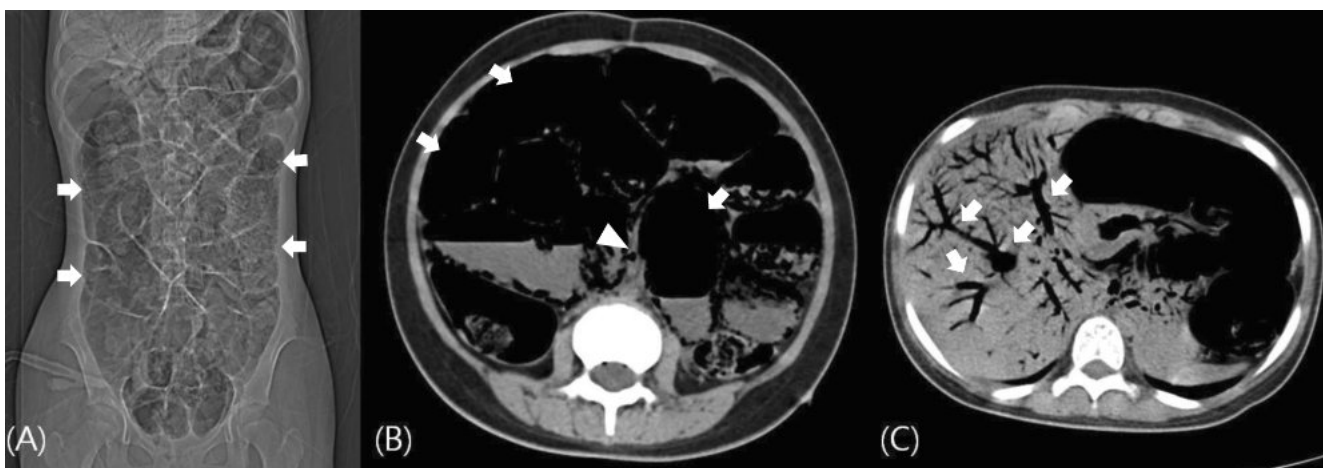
Computed tomography images of the abdomen and pelvis. (A) Aggravated state of gaseous collections in small bowel loops (arrows). (B) Generally distended small bowel and large bowel (arrows) showing air density in the bowel wall (arrowhead). (C) Marked portal venous gas (arrows). Pneumatosis intestinalis with gas bubbles in the portal vein and its branches, mesenteric vein was suggestive of gangrenous bowel perforation.
